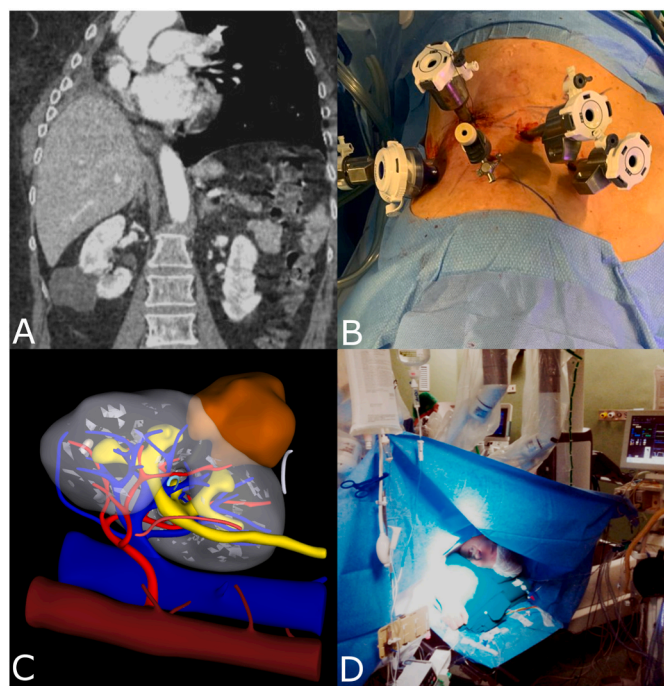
A: Preoperative CT-scan; B: Port placement; C: 3D reconstruction of the right kidney and of the tumor mass; D: Awake patient during the procedure (left decubitus position).
